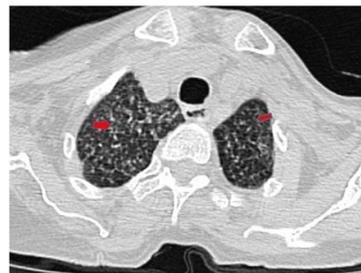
HRCT Axial section of upper thorax: Multiple tiny random dense miliary nodules (red arrow) seen in apical segments of bilateral upper zone.
